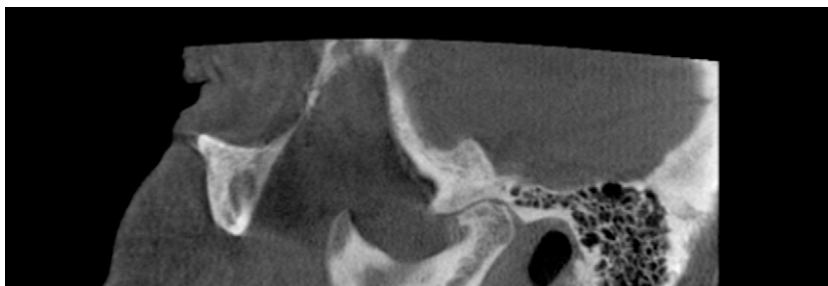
CBCT of osteoarthritis: osteophyte, sclerosis, flat articular surfaces, erosion and possible subchondral cyst (female, 68 years).
